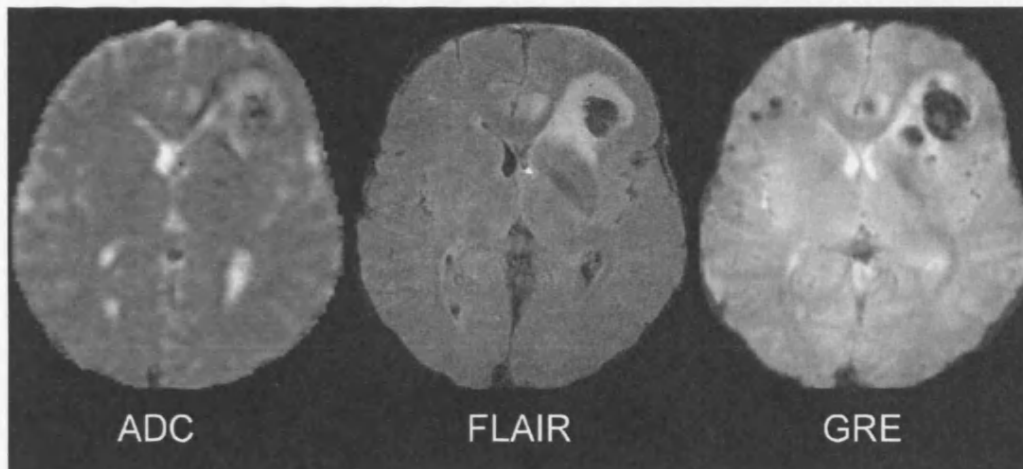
Coregistered image sets from a patient imaged 21 hours after injury. ADC image (left), FLAIR image (middle) and GRE image (right). A large left frontal contusion with a hypointense core is shown on all three image sequences, indicating the presence of haematoma. The hyperintensity surrounding these core regions is uniform on FLAIR images but of mixed density on the ADC images, this is a common finding and demonstrates that tissue with T2 hyperintensity may have heterogeneous diffusion characteristics. The hypointense rim of tissue outside this hyperintensity is seen on ADC but is absent on GRE, excluding haematoma as a cause of this hypointensity.
